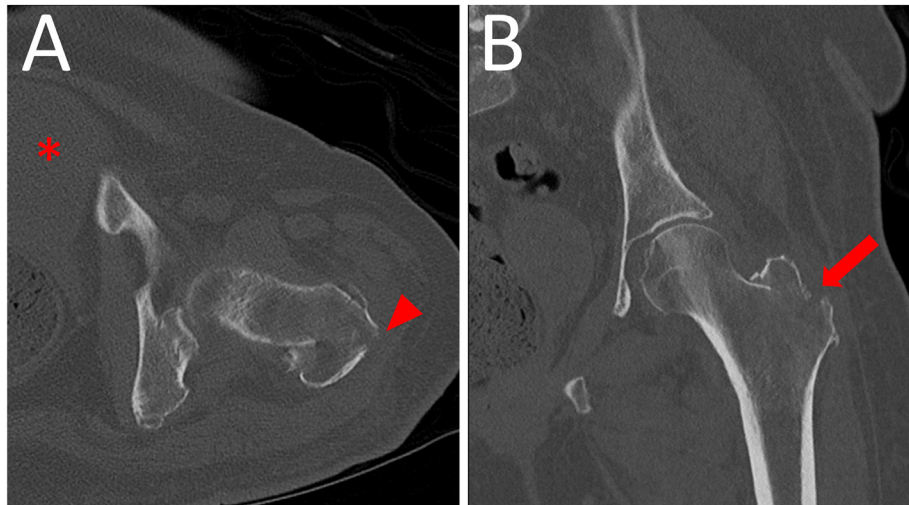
Computed Tomography of the hip. CT demonstrates the presence of left hip intertrochanteric (arrowhead) and greater trochanter (arrow) fractures. An enlarged uterus is incidentally visualized (asterix).
